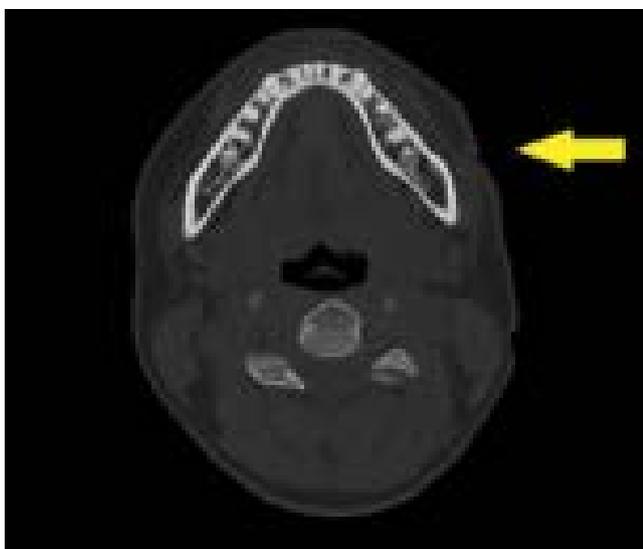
Computed tomography scan in axial section shows crater-like skin retraction and cortical layer obliteration of the anterolateral mandibular surface.
